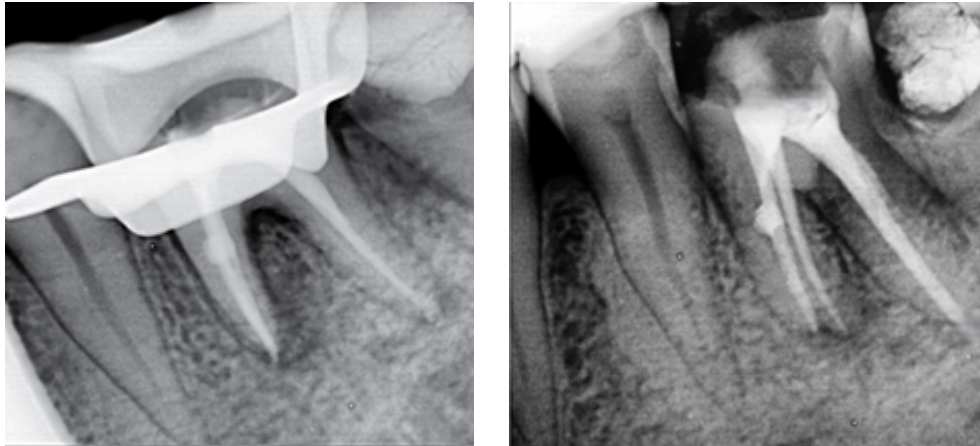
Postobturation radiograph.
